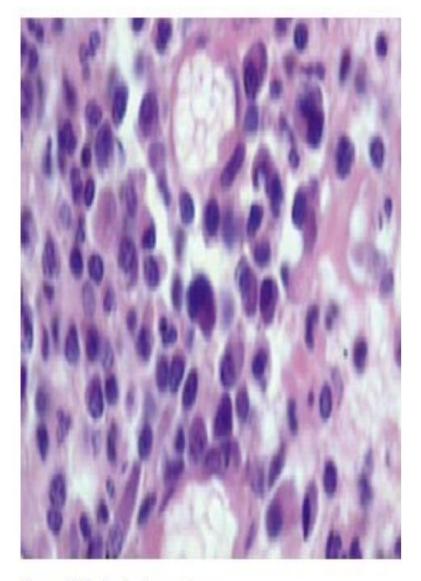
Periapical granuloma
